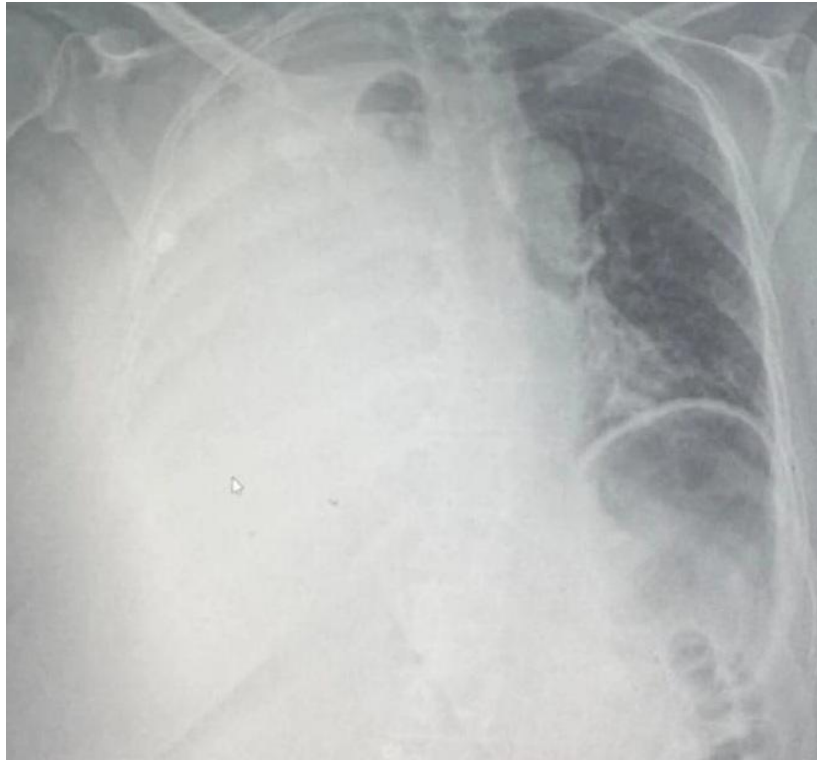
Chest radiograph demonstrating a massive unilateral pleural effusion involving the left hemithorax, consistent with a large pleural collection and compressive change in the adjacent lung.
